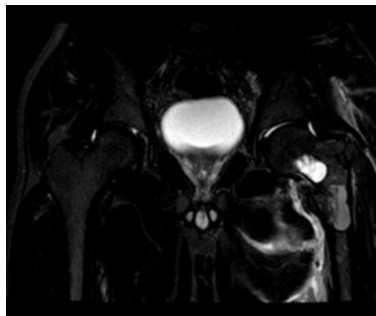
T2 slice on MRI at the initial presentation of the patient
